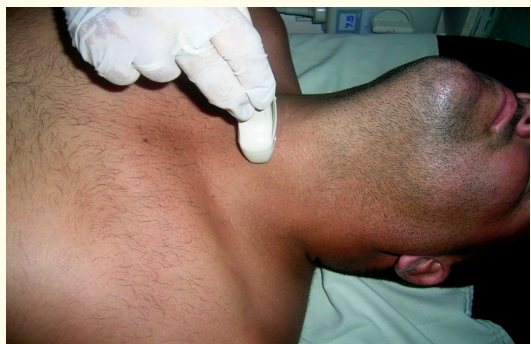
Transducer position for the ultrasound of trachea.
